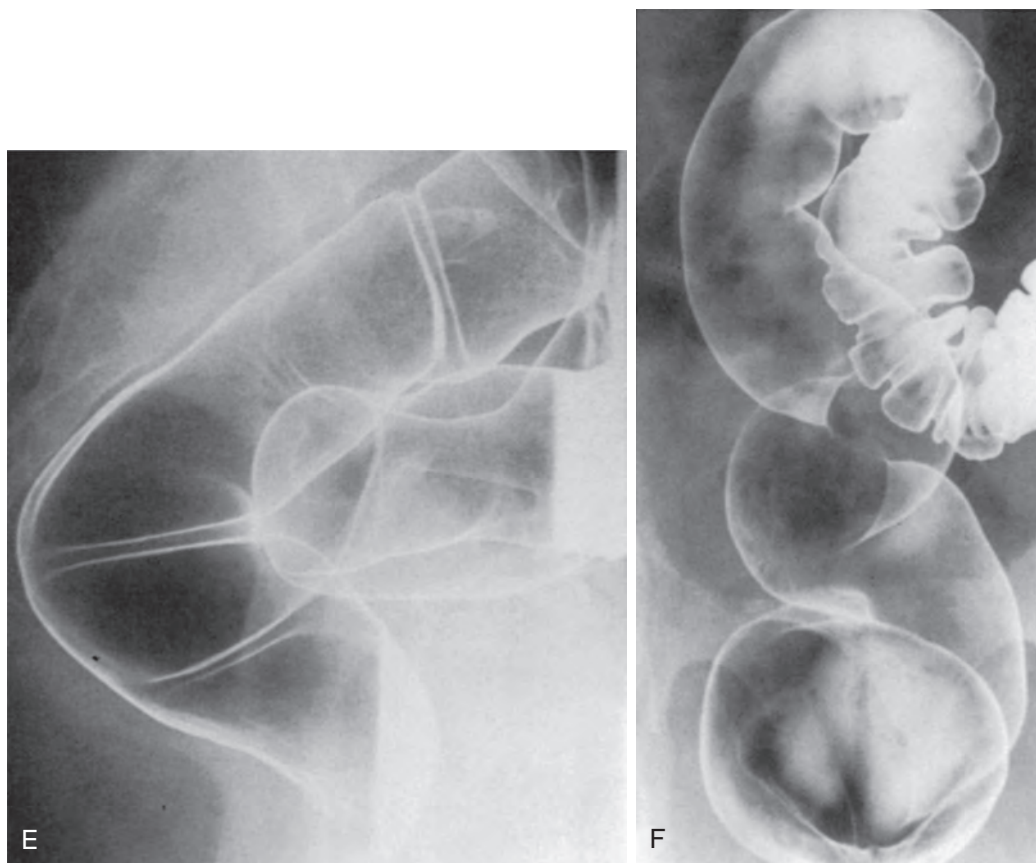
cont'd E. Prone, cross-table lateral overhead radiograph of the rectum. F. Coned-down view of prone angled radiograph of the rectosigmoid colon. (B and D from Laufer I, Levine MS [eds]: *Double Contrast Gastrointestinal Radiology*, 2nd ed. Philadelphia, WB Saunders, 1992.)
